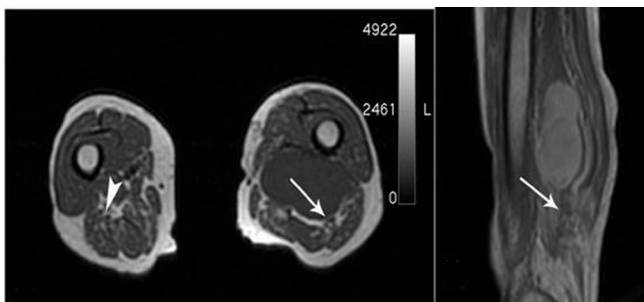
Axial T1-weighted and sagittal T2-weighted images demonstrating a soft-tissue mass within the posterior femoral compartment, the close relation of the mass to the sciatic nerve is seen (arrows). Normal sciatic nerve is seen in the posterior area of right thigh (arrow head).
